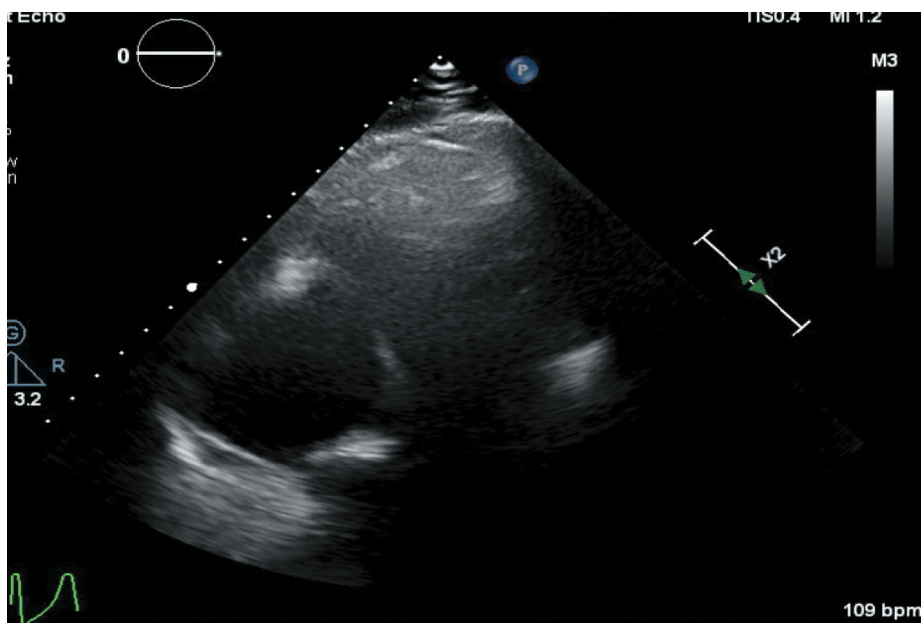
Transthoracic echocardiogram status post tricuspid valve extirpation on hospitalization day 15.
